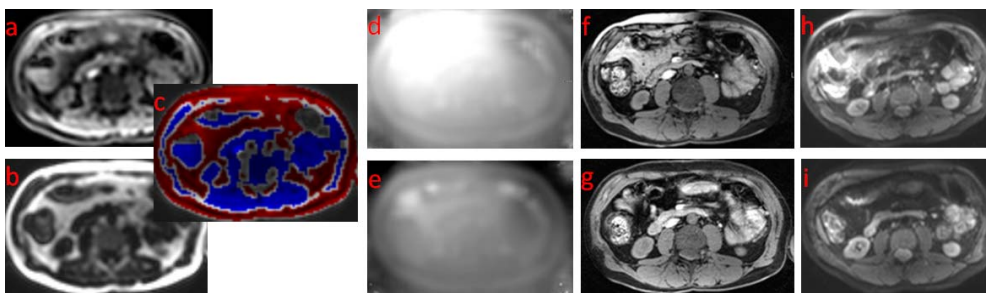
Water, Fat, B0, DWI and fat suppressed FFE images obtained on volunteer 7 (cf: Fig. 2)
